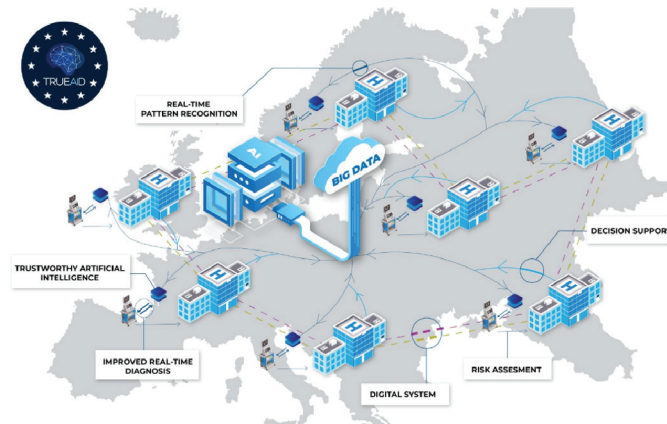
Implementation of TRUEAID through integration in ultrasound devices
